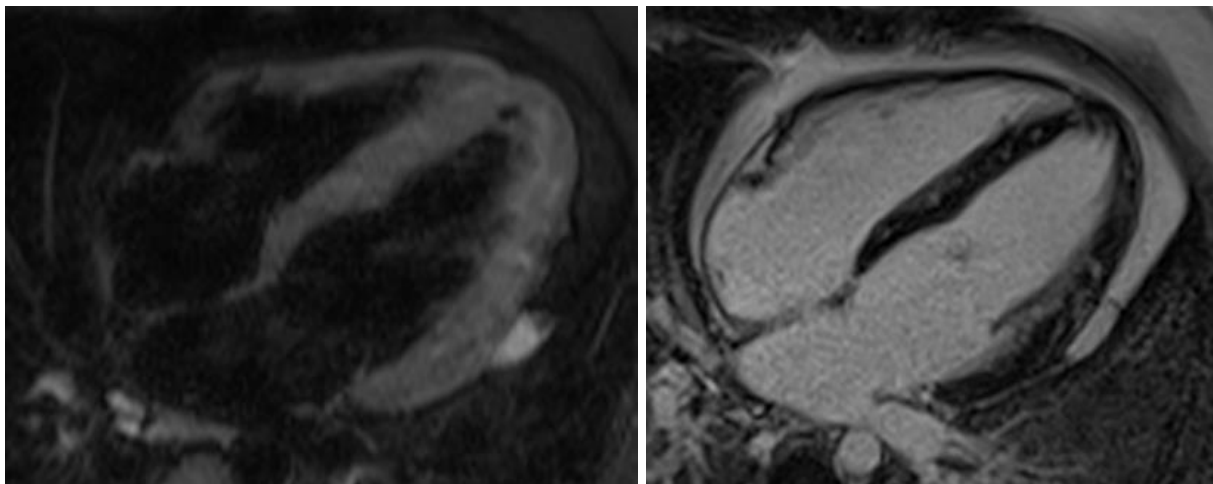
Examples of myocarditis MRI pictures. Left: T2 weighted; Right: *LGE* (typical edema and intramural LGE pattern in myocarditis).
